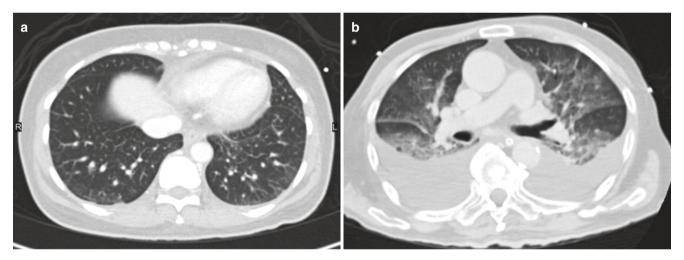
CT findings of hydrostatic pulmonary edema. (a) Axial CT images in lung window show smooth interlobular septal thickening at lung bases during the early stage of pulmonary edema, (b) progressing
